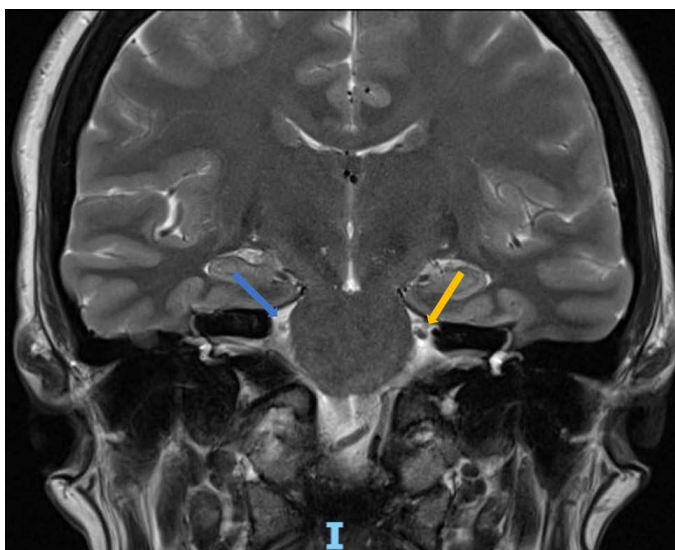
FINDINGS: Sagittal T2 SPACE MRI of the brain demonstrates atrophy of right cisternal trigeminal nerve (blue arrow) and a normal left trigeminal nerve (yellow arrow).
